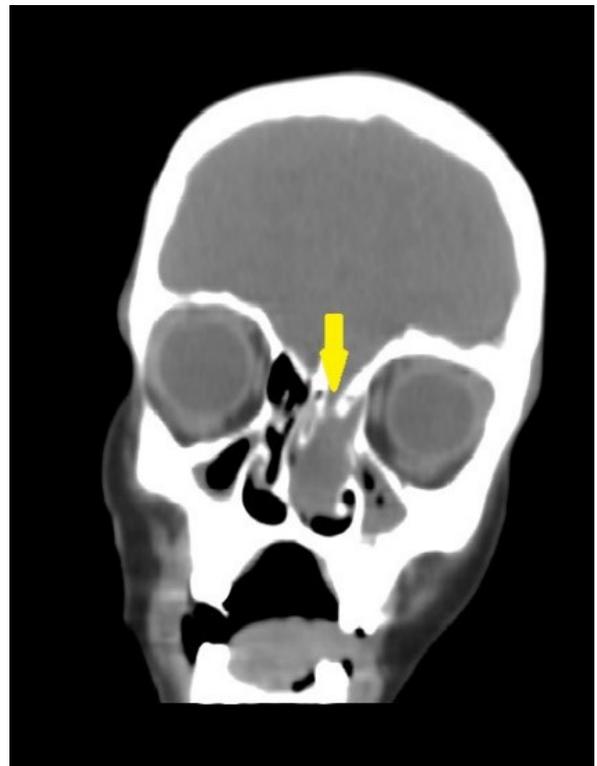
On coronal reformed CT images, a bony defect is seen on left lamina cribrosa. (yellow arrow). Heterogenous image of encephalocele and mucosal tissue is seen on the left ethmoid sinus and nasal cavity.
